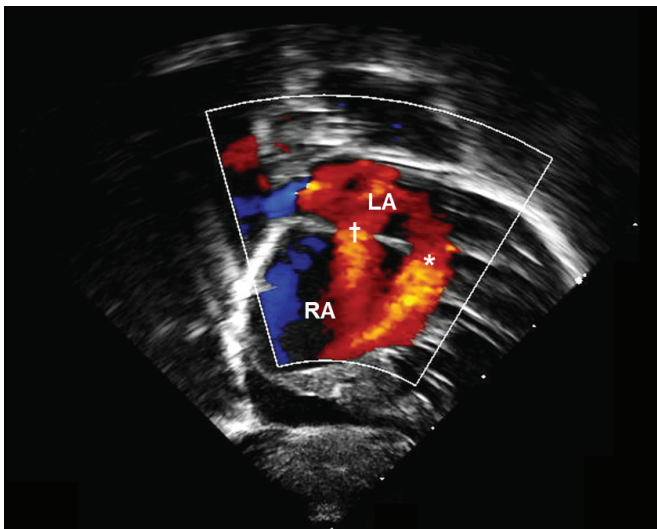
Echocardiogram, 4-chamber view demonstrating left-to-right shunting through the septum primum atrial septal defect.
